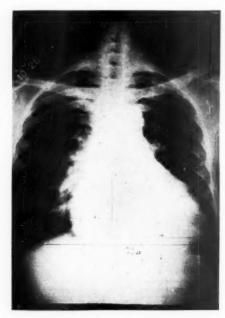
X-ray photograph (7-foot plate) of the heart in Case 2. Note the increase in the cardiac shadow both to the right and left.
